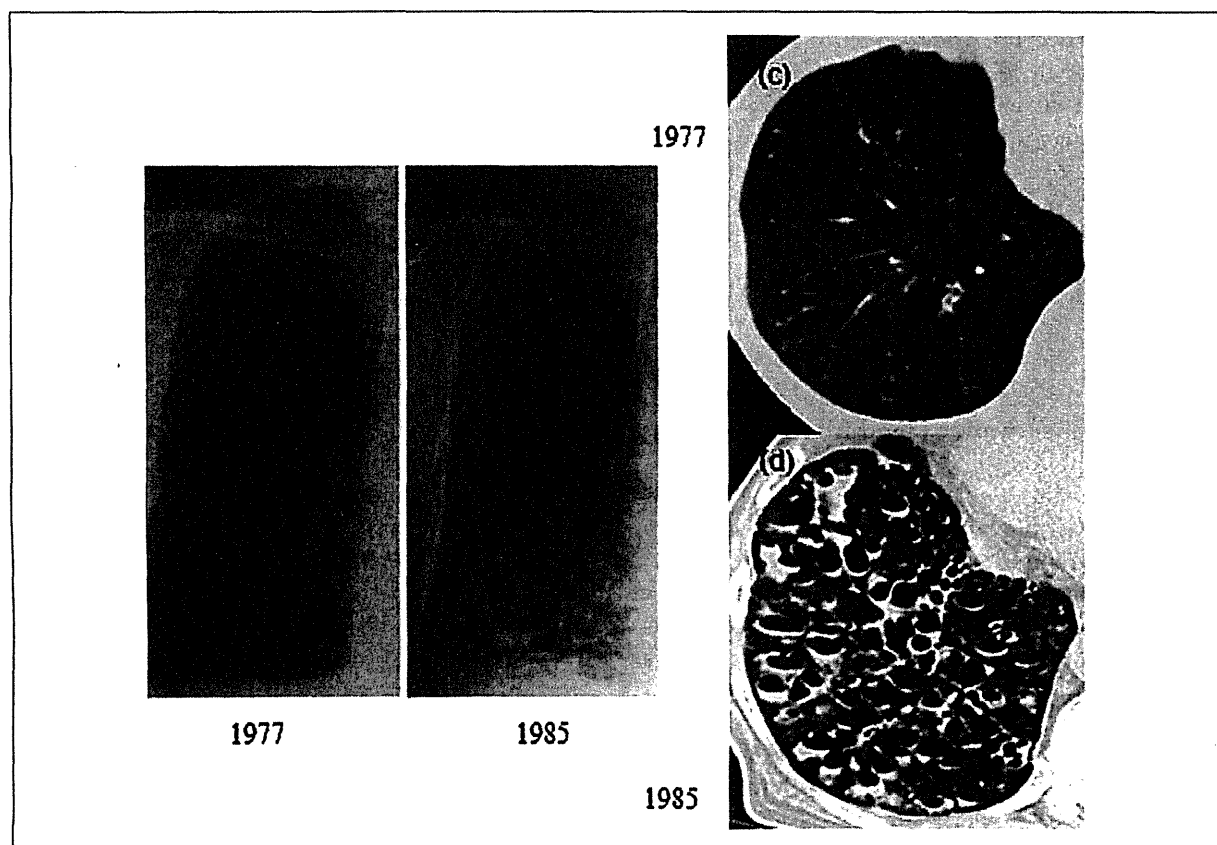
Chest X-ray and CT findings in Case #7 (a) Chest X-ray and (c) CT in 1977 showing diffuse centrilobular nodules. (b) Chest X-ray and (d) CT in 1985 progressing to diffuse bronchiectasis
